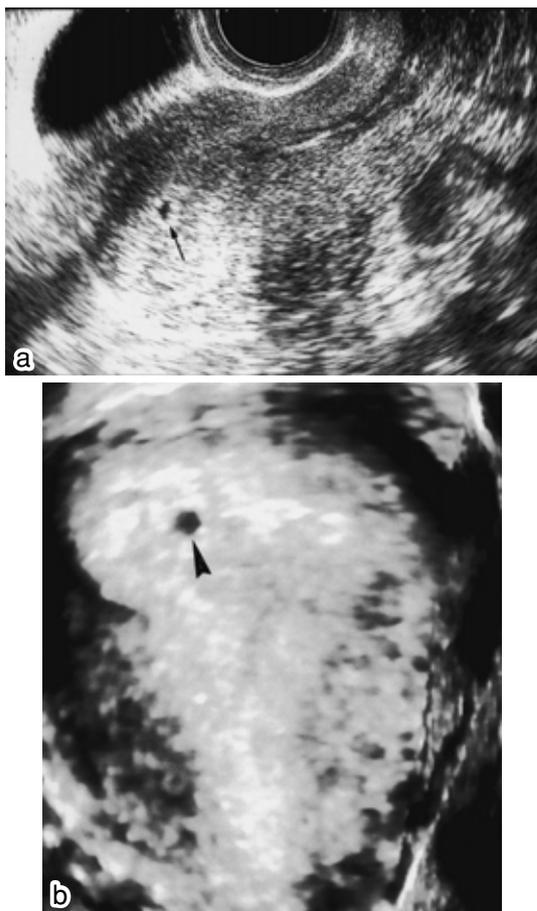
Detection of GS (arrow) with two-dimensional ultrasound (a), and the same GS (arrowhead) with three-dimensional ultrasound (b)
